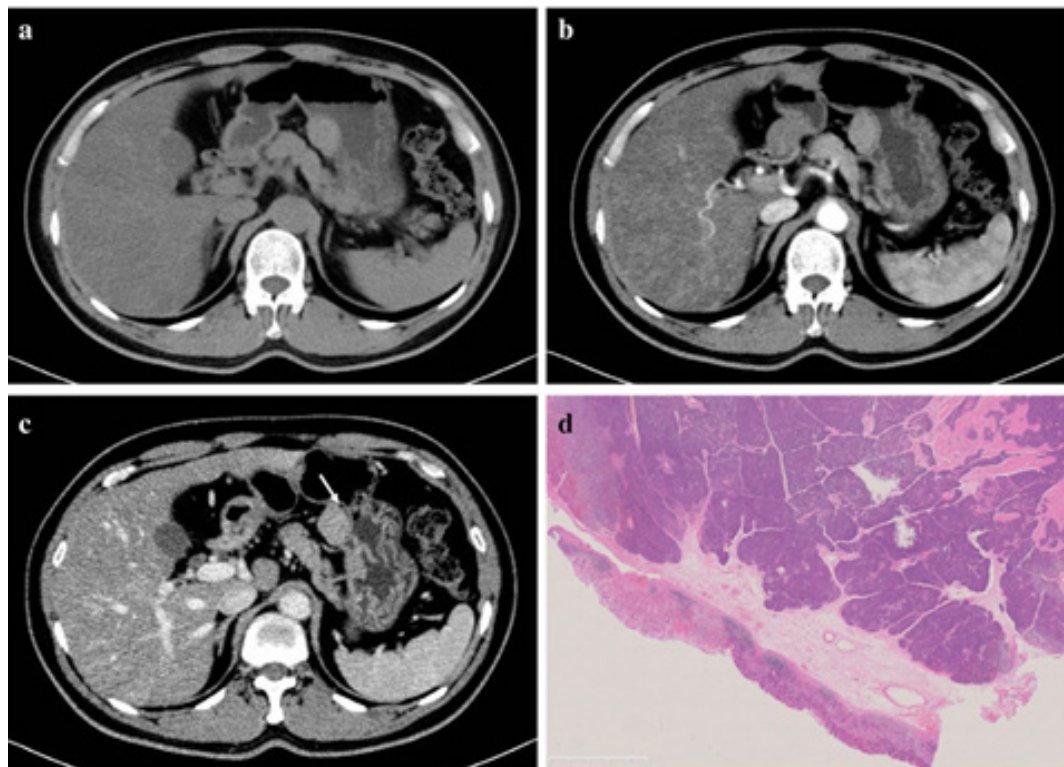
Ectopic pancreas in gastric body (a–c). Axial computed tomography scans (nonenhanced, arterial and portal phase) show an oval exophytic mass in the gastric body and also the fat-line of peritumor (arrow). The lesion shows homogeneous enhancement and equal attenuation to the pancreas (d). The lesion was confirmed as ectopic pancreas pathologically.
